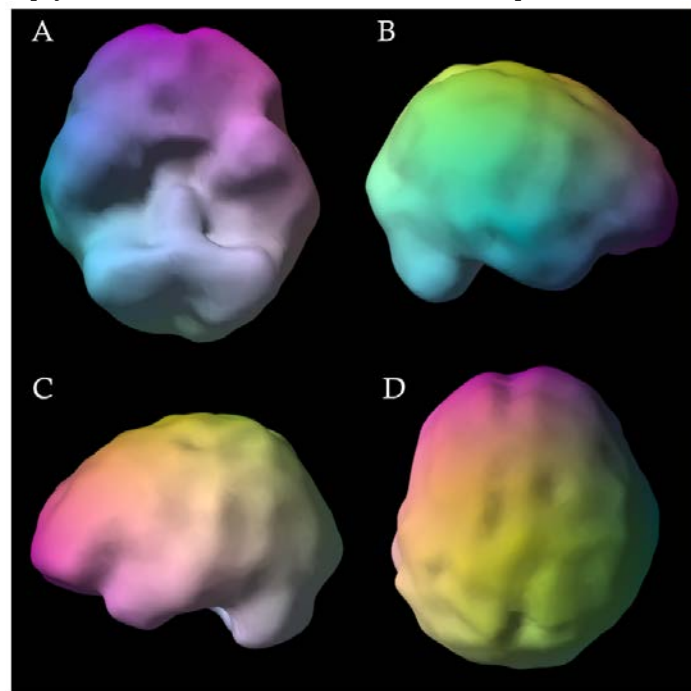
Surface-rendered brain perfusion SPECT images. Resting surface-rendered images demonstrating relative regional tracer distribution. (A) Inferior (underside) view. (B) Right lateral view. (C) Left lateral view. (D) Superior (top-down) view. Relatively decreased tracer activity was described in the bilateral temporal, medial dorsal prefrontal, medial dorsal parietal, prefrontal pole, bilateral occipital, and cerebellar regions, with additional very mild right dorsal prefrontal and right parietal decreases and very mild scalloping. The color-rendered findings represent qualitative differences in relative tracer intensity and do not provide absolute cerebral blood flow measurements. SPECT, single-photon emission computed tomography
